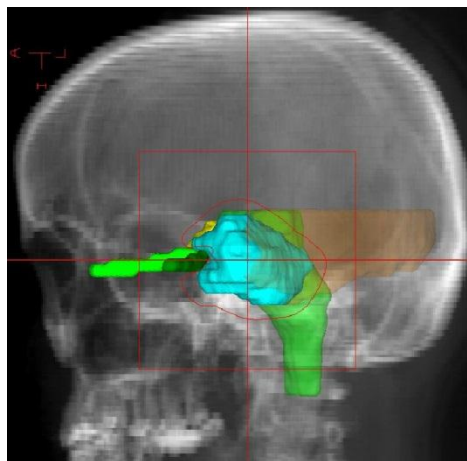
Digital reconstructed X-ray of the patient's skull with the projection of the target, critical structures (brain stem, optic nerves, temporal lobe) and the shape of the Figure collimator for this direction of irradiation.
